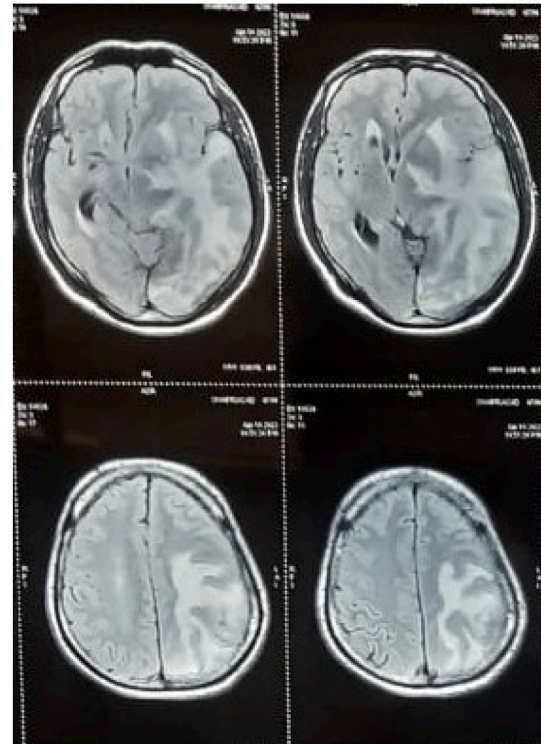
are the magnetic resonance imaging of brain showing an irregular ill-defined lesion involving the temporoparietooccipital lesion involving the tentorium cerebelli and dura with significant mass effect and edema.
